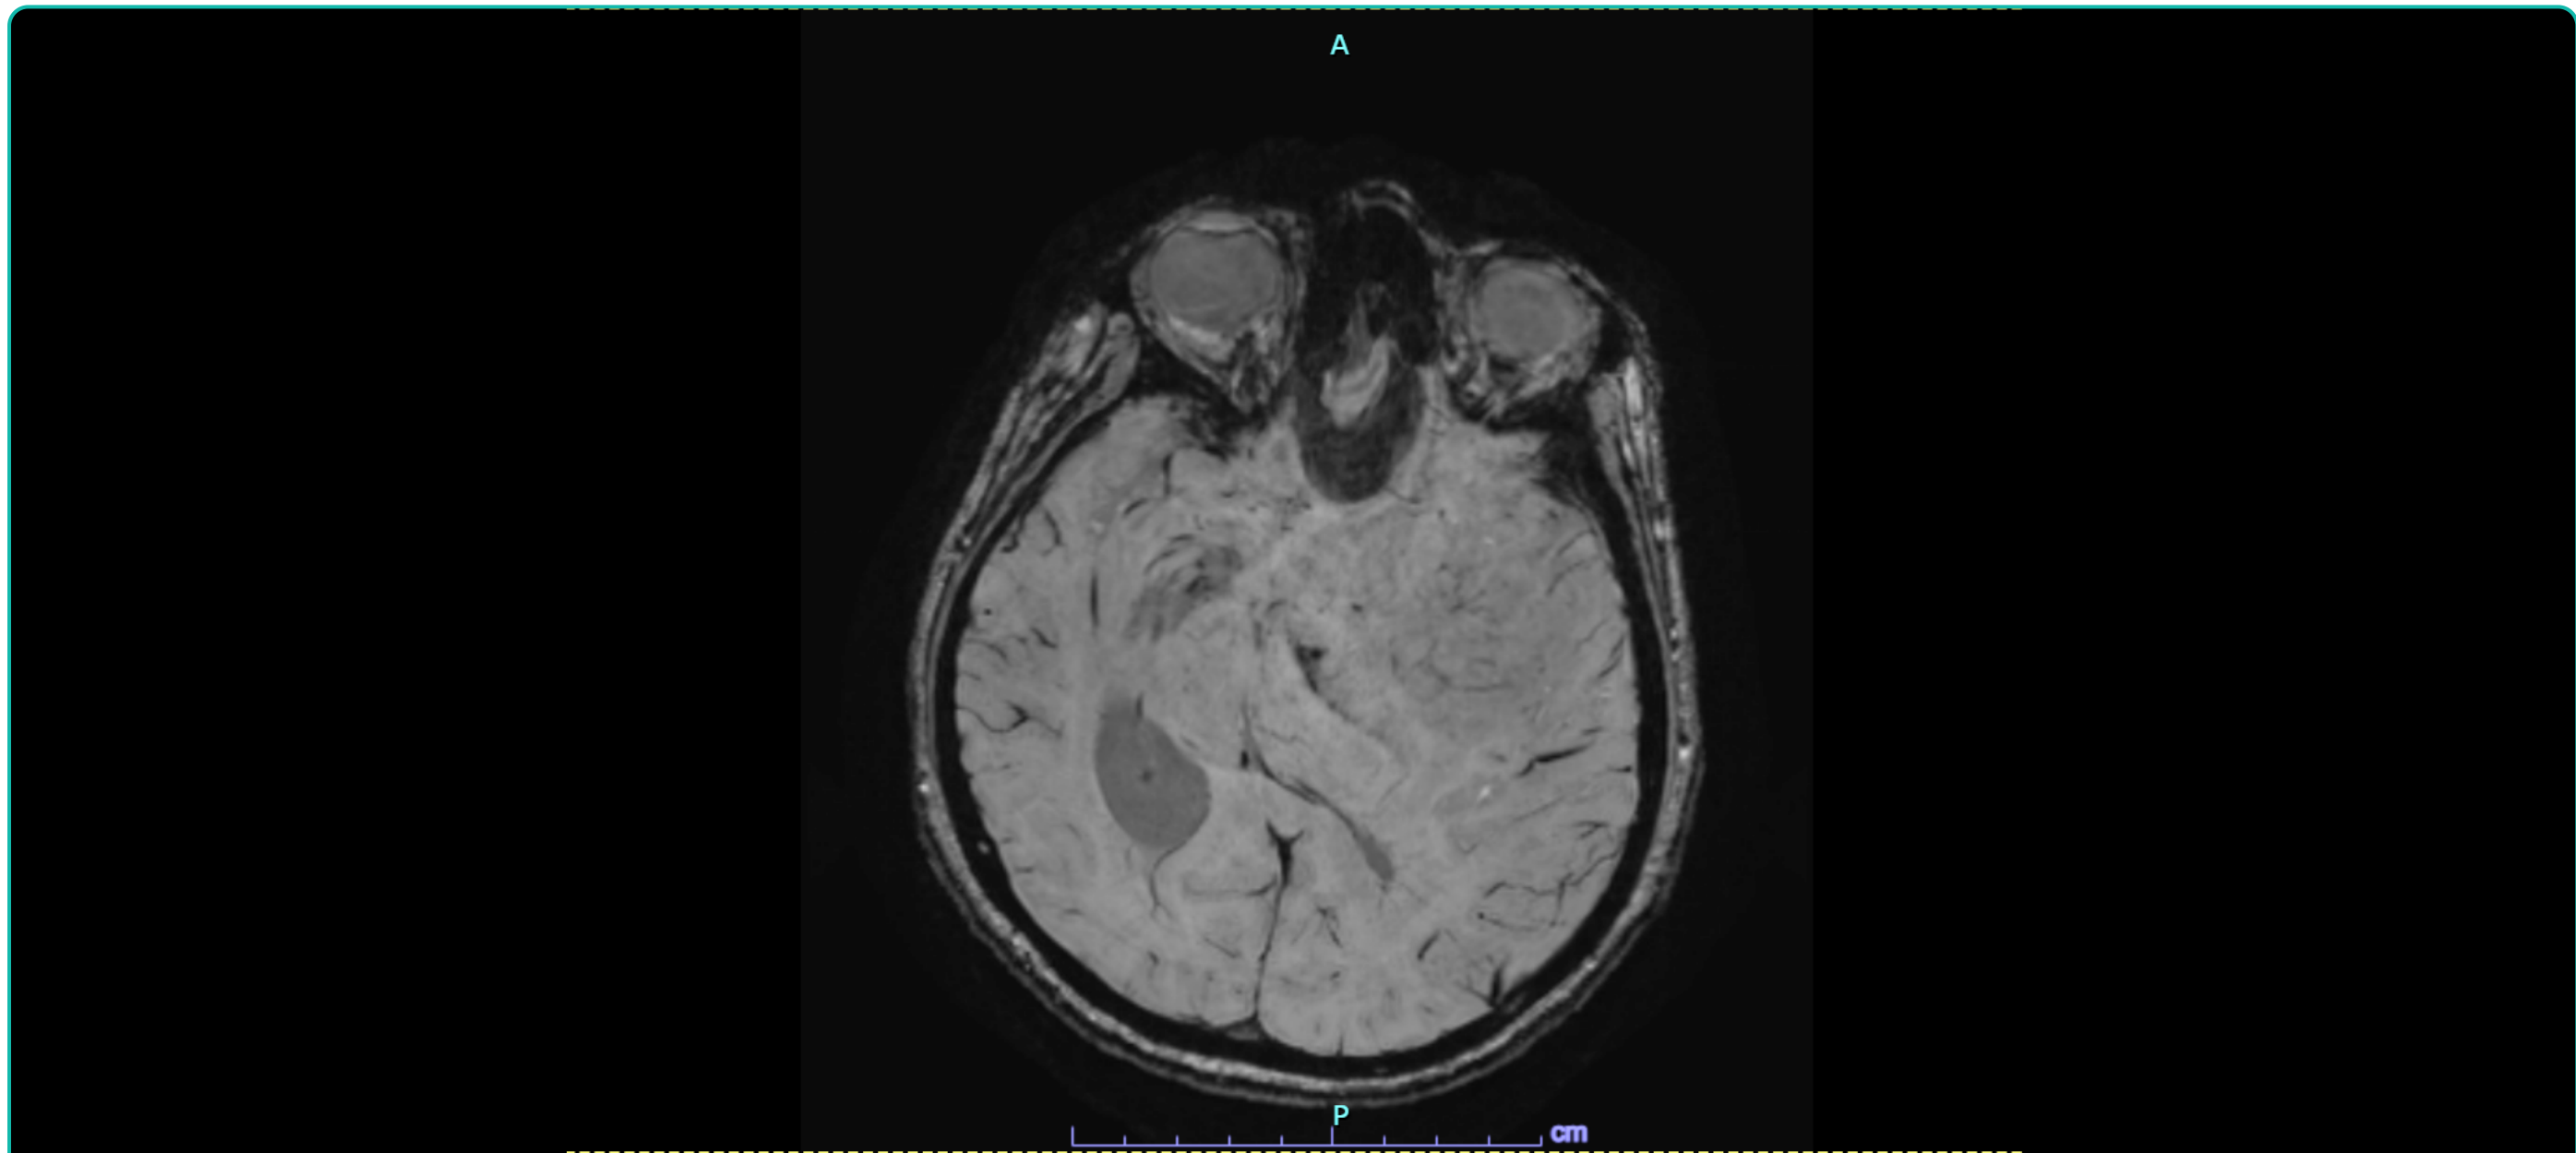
Pre-operative Head MRI with Gadolinium Contrast
